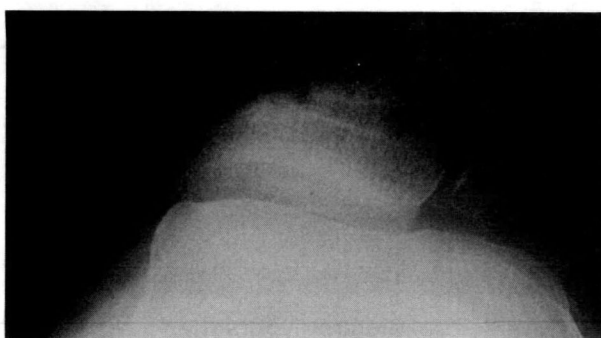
A postoperative roentgenogram of the knee in case 2. : The tilting angle improved to 5° and the lateral shift ratio improved to 10%.
